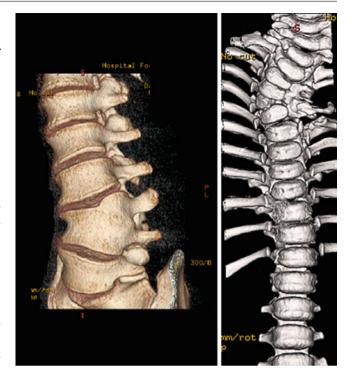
Reconstructive CT images showing a partially segmented and fully segmented hemivertebrae
